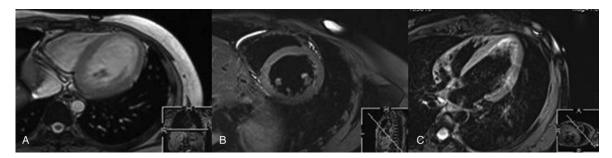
Magnetic resonance imaging scan 50 days after admission (4-chamber view [A] short-axis view [B] long-axis chamber view [C]) showing high-signal intensity in the left ventricular wall distribution.
